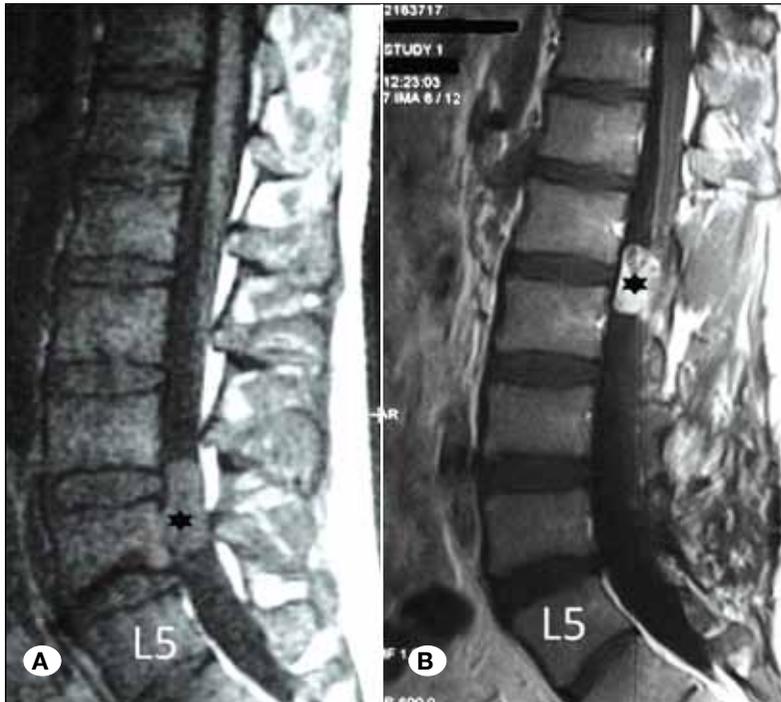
A) A small, well-circumscribed, heterogeneous hypo-intense mass (asterisk) at L3-4 levels on sagittal T1-weighted MRI scans, B) A newly raised, small, well-circumscribed, heterogeneous hypo-intense mass (asterisk) at L1-2 levels on sagittal T1-weighted MRI 8 years after the previous tumor excision.
